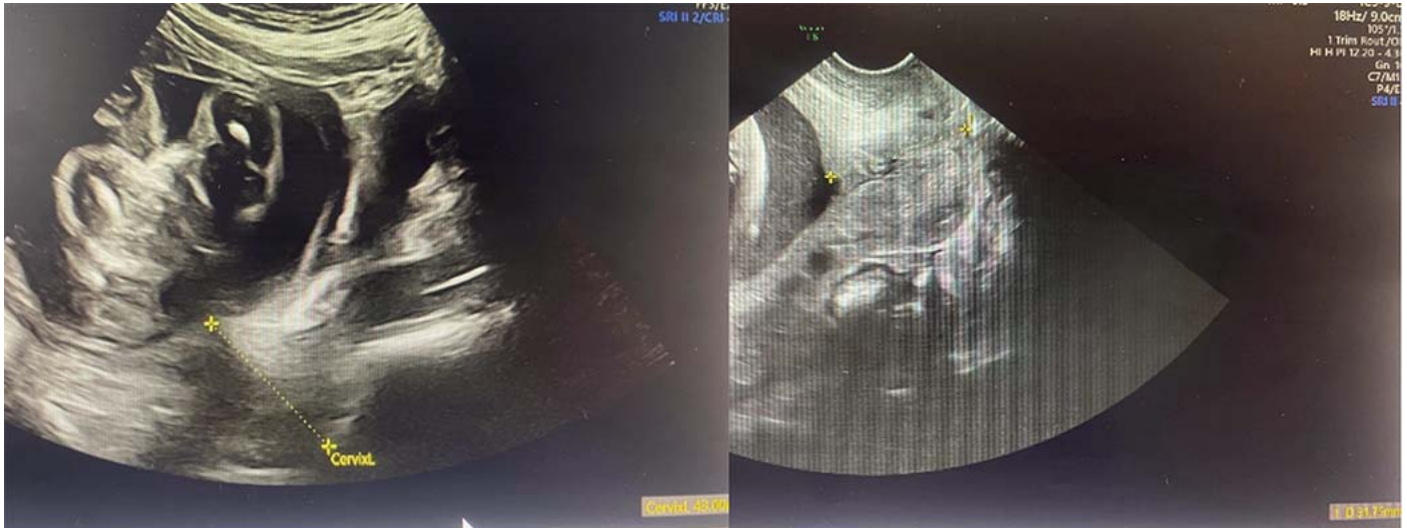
Pictures 1a and 1b depict the cervical length measurement by transabdominal and transvaginal ultrasound, respectively.
